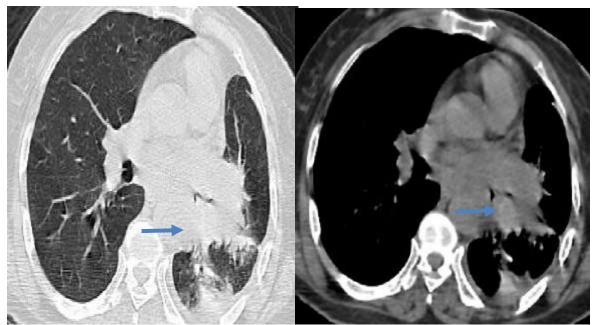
The chest CT scan showing a left pulmonary hilo process.
